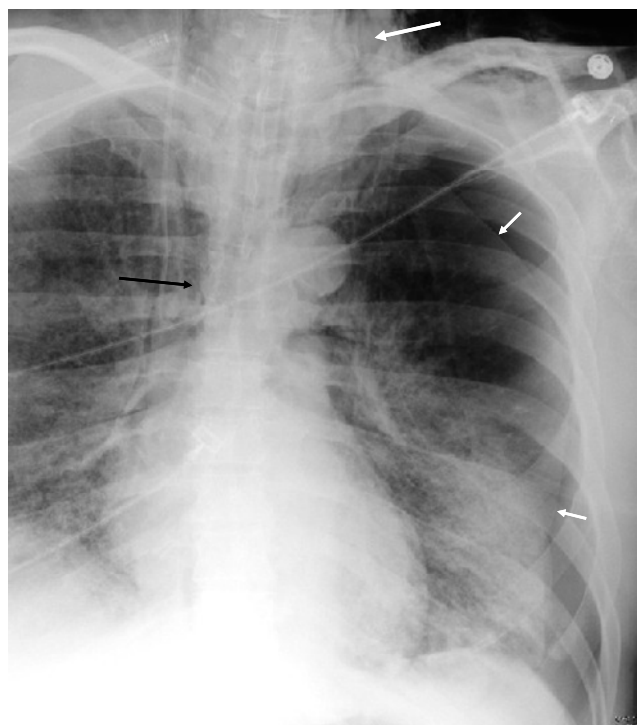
AP chest radiograph reveals pneumothorax (short arrows), pneumomediastinum (long black arrow), subcutaneous emphysema (long white arrow), and bibasilar reticulonodular ground-glass opacities.
